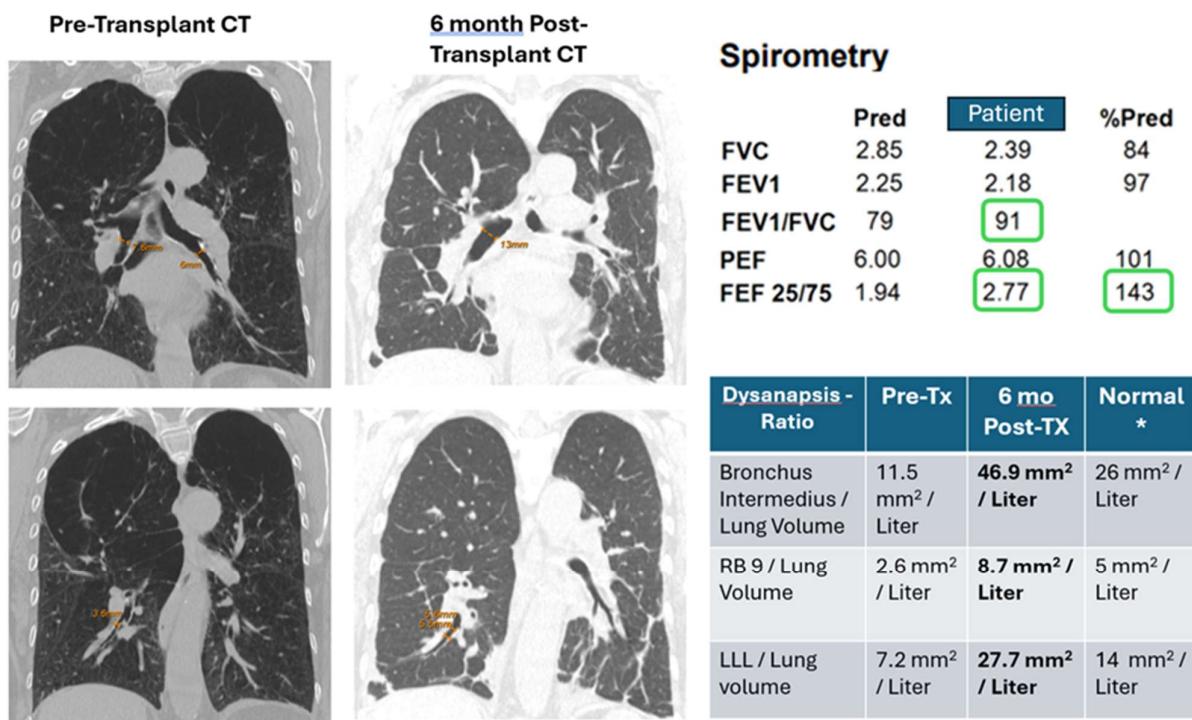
Pre-transplant and 6 months post-transplant CT scan images in coronal view with airway dimension measurements. Airway size to lung size ratio (Dysanapsis ratio) calculations comparing pre-transplant, to post-transplant and normal values are in the table at bottom right (reference: doi:10.1152/japplphysiol.00562.2009). Spirometry at 12 months after transplant (top right); The green boxes highlight supranormal expiratory airflow.
